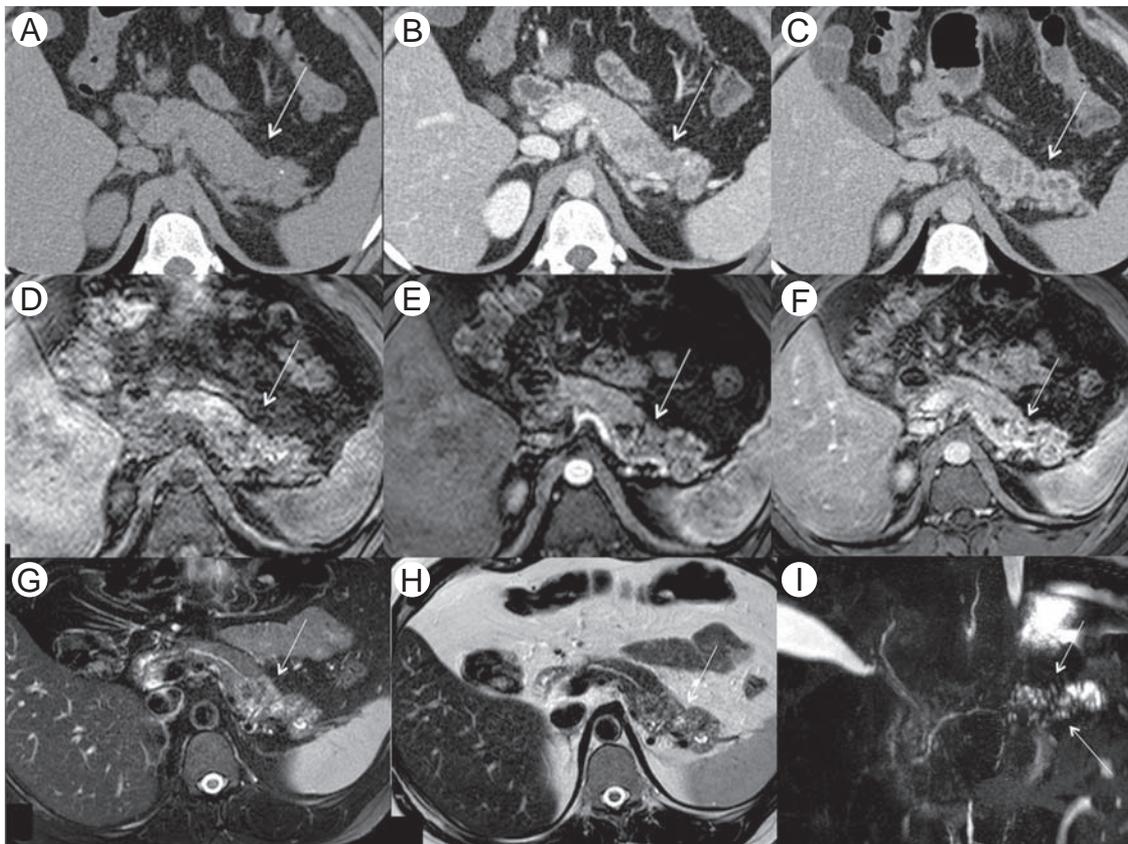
Focal chronic pancreatitis in a 33-year-old man with history of chronic alcoholism who was submitted to distal pancreatectomy. Unenhanced (A), portal (B), and delayed (C) phases of CT scan show a heterogeneous area in the tail of the pancreas (arrows) with cysts (suggestive of ductal dilatation) and punctate calcifications. Unenhanced (D), arterial (E), and portal (F) axial T1-W 3D GRE images confirm these findings (arrows). T2-W images with (G) and without (H) fat-suppression better detail the cysts, suggestive of ductal dilatation in the pancreatic tail (arrows). Thick-slab coronal MR cholangiopancreatography image (I) shows multiple small cysts around the main pancreatic duct (arrows), suggestive of dilatation of secondary ducts, mimicking intraductal papillary mucinous neoplasm.
